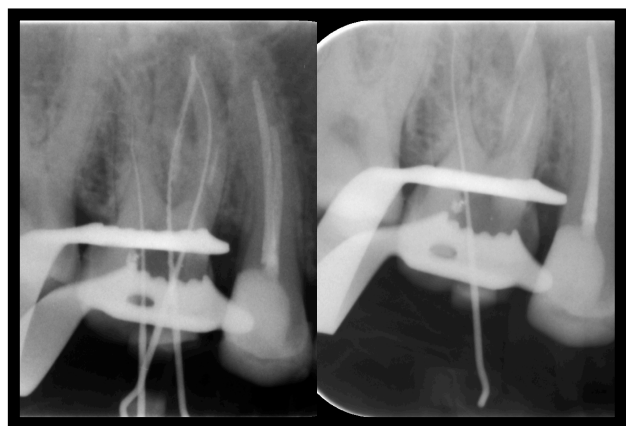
Working length radiographs
